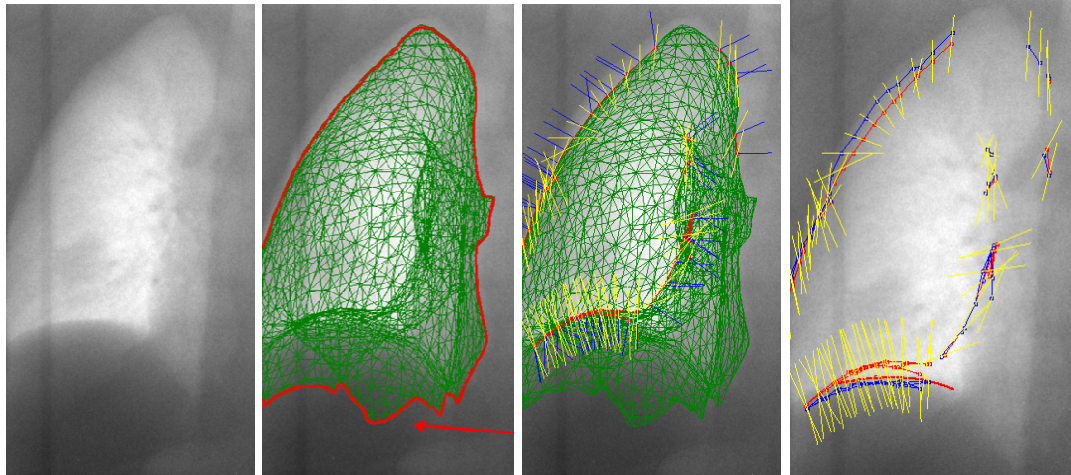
(a) Original MVCBCT projection image; (b) The projection of the initial lung mesh (green) and the silhouette contour (red). Note that the part of the contour at the bottom does not have corresponding strong gradient. (c) Projected initial lung mesh (green), detected candidate edge (red contour), projected motion direction (yellow line), projected normal direction (blue line); (d) original candidate edge (red), projected motion direction (yellow line), deformed candidate edge after optimal graph search (blue).
